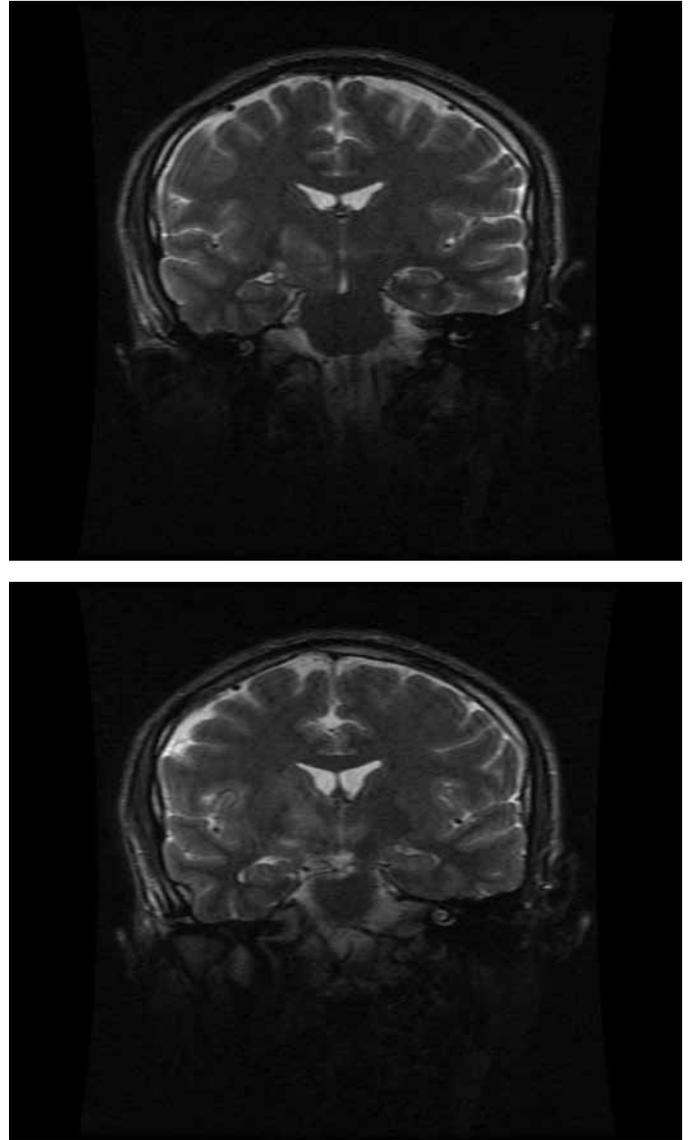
Pre-treatment coronal T2 MRI
